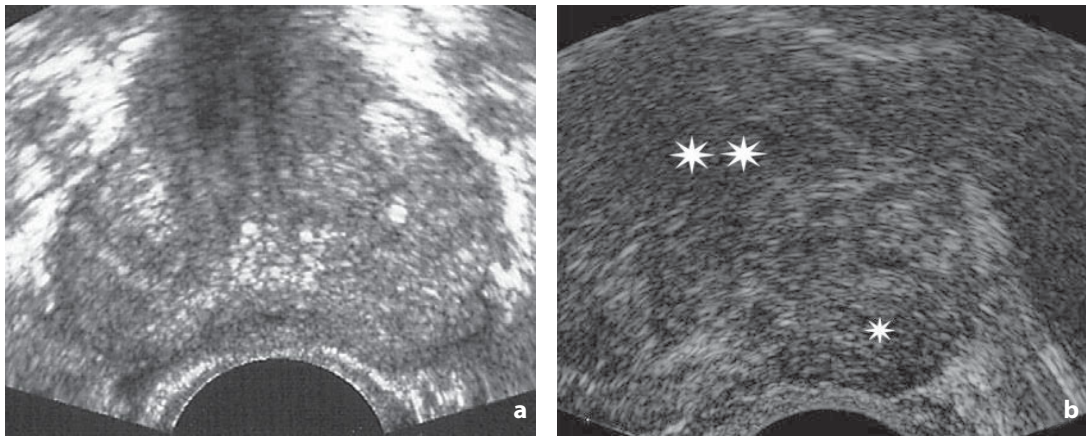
Ultrasonography. Transrectal approach. Prostatic adenocarcinoma. a Isoechoic lesion. Patient with PSA 8 ng/mL. The random biopsies show the presence of adenocarcinoma in the right peripheral zone. A centrally located trilobar adenoma is also visible. b Detailed view of hypoechoic lesion (*asterisk*) located in the peripheral zone of the left lobe. At US-guided targeted biopsy granulomatous prostatitis is diagnosed. The gland shows diffusely coarse echotexture prevalently hypoechoic in the central zone (*double asterisk*)
